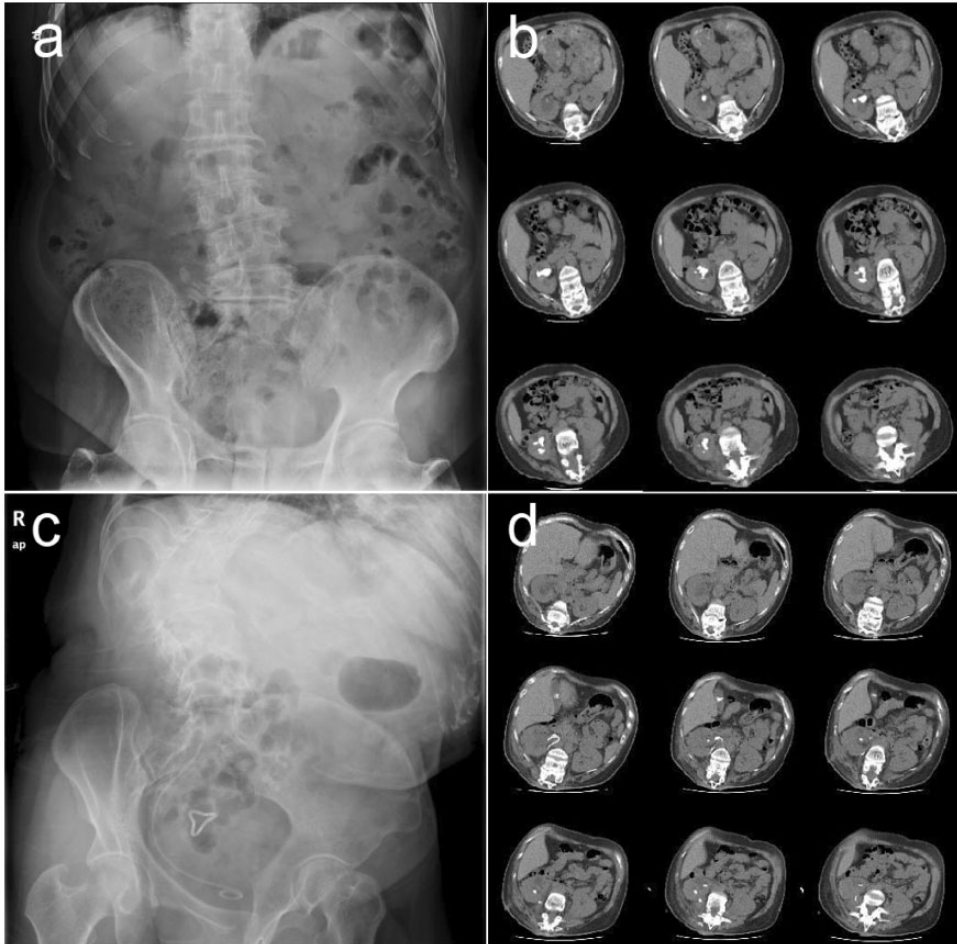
(a) Kidney–ureter–bladder plain film and (b) abdominal plain computed tomography image before the first operation. (c) Kidney–ureter–bladder film and (d) computed tomography image 3 days after the first operation.
